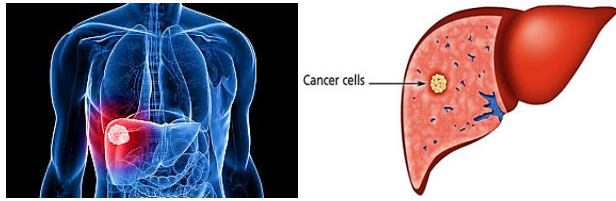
Ultrasound Image for Liver cancer cell detection [11].
